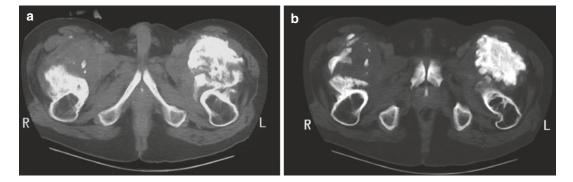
(a, b) Posttraumatic myositis ossificans, mature stage, anteriorly in the proximal third of both thighs in a 33-year-old man: (a) CT at the level of the lesser trochanter of the femur (soft tissue window setting);
